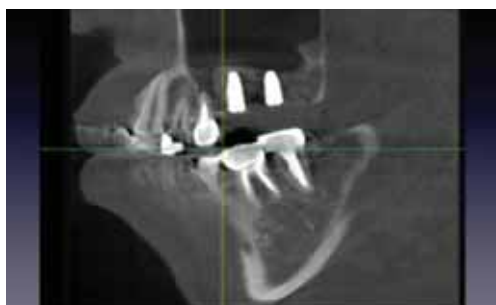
CT scan after implant placement.
